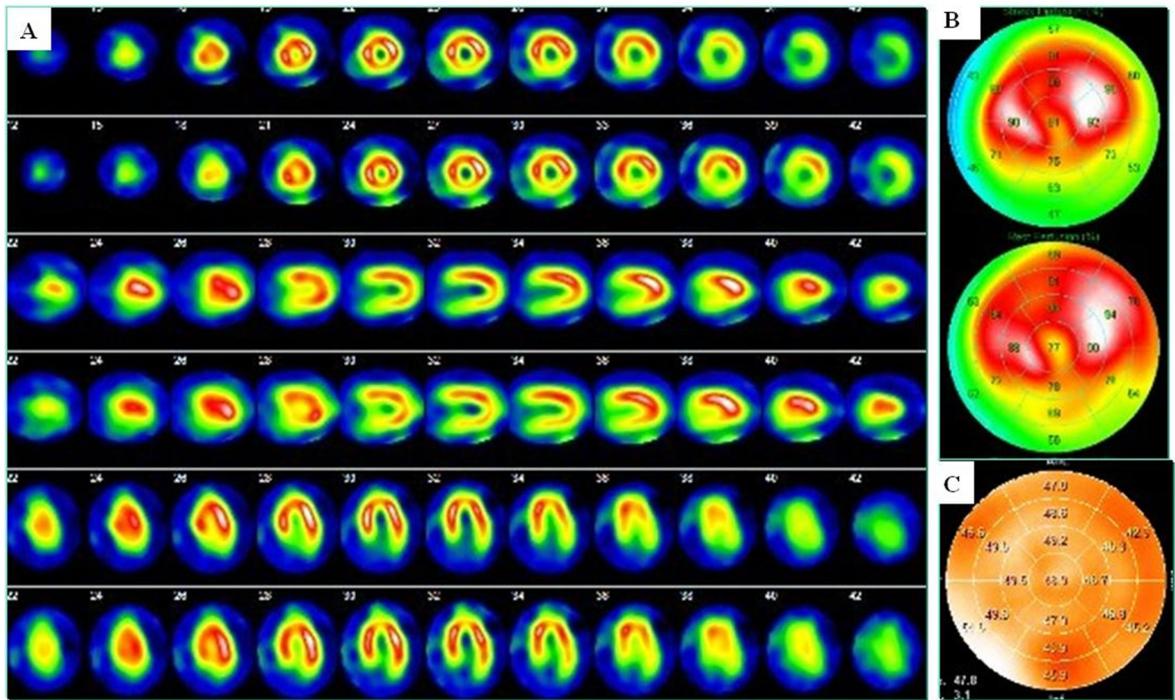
Stress myocardial perfusion scintigraphy with ^{201}Tl chloride induced by adenosine. (A) Partial redistribution in inferior portion was found on single-photon emission computed tomography findings. (B) Partial redistribution in inferior portion was observed on Bull's eye findings. (C) Washout rate was 47.8%.
